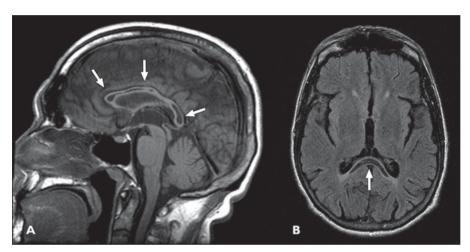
53-year-old alcoholic man affected by Marchiafava-Bignami disease. A, Multiple cavitations and atrophy of corpus callosum are noted (*arrows*) on sagittal T1-weighted images. B, Axial FLAIR image shows cavitations of splenium of corpus callosum (*arrow*).
